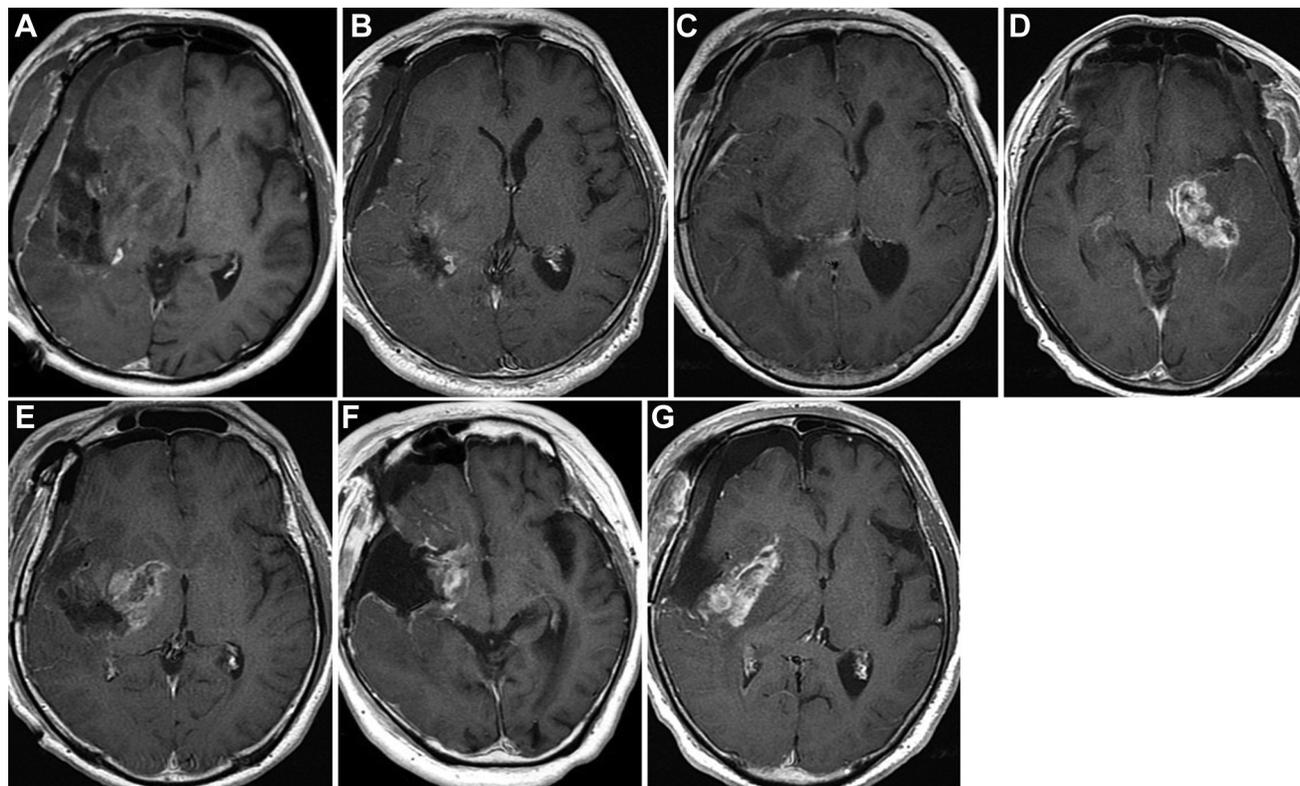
Postoperative axial gadolinium-enhanced T1-weighted magnetic resonance imaging of 7 cases of medial temporal glioblastomas. (A–G) Cases 1 to 7, respectively. (A–D) Mimicking type allowing extensive
